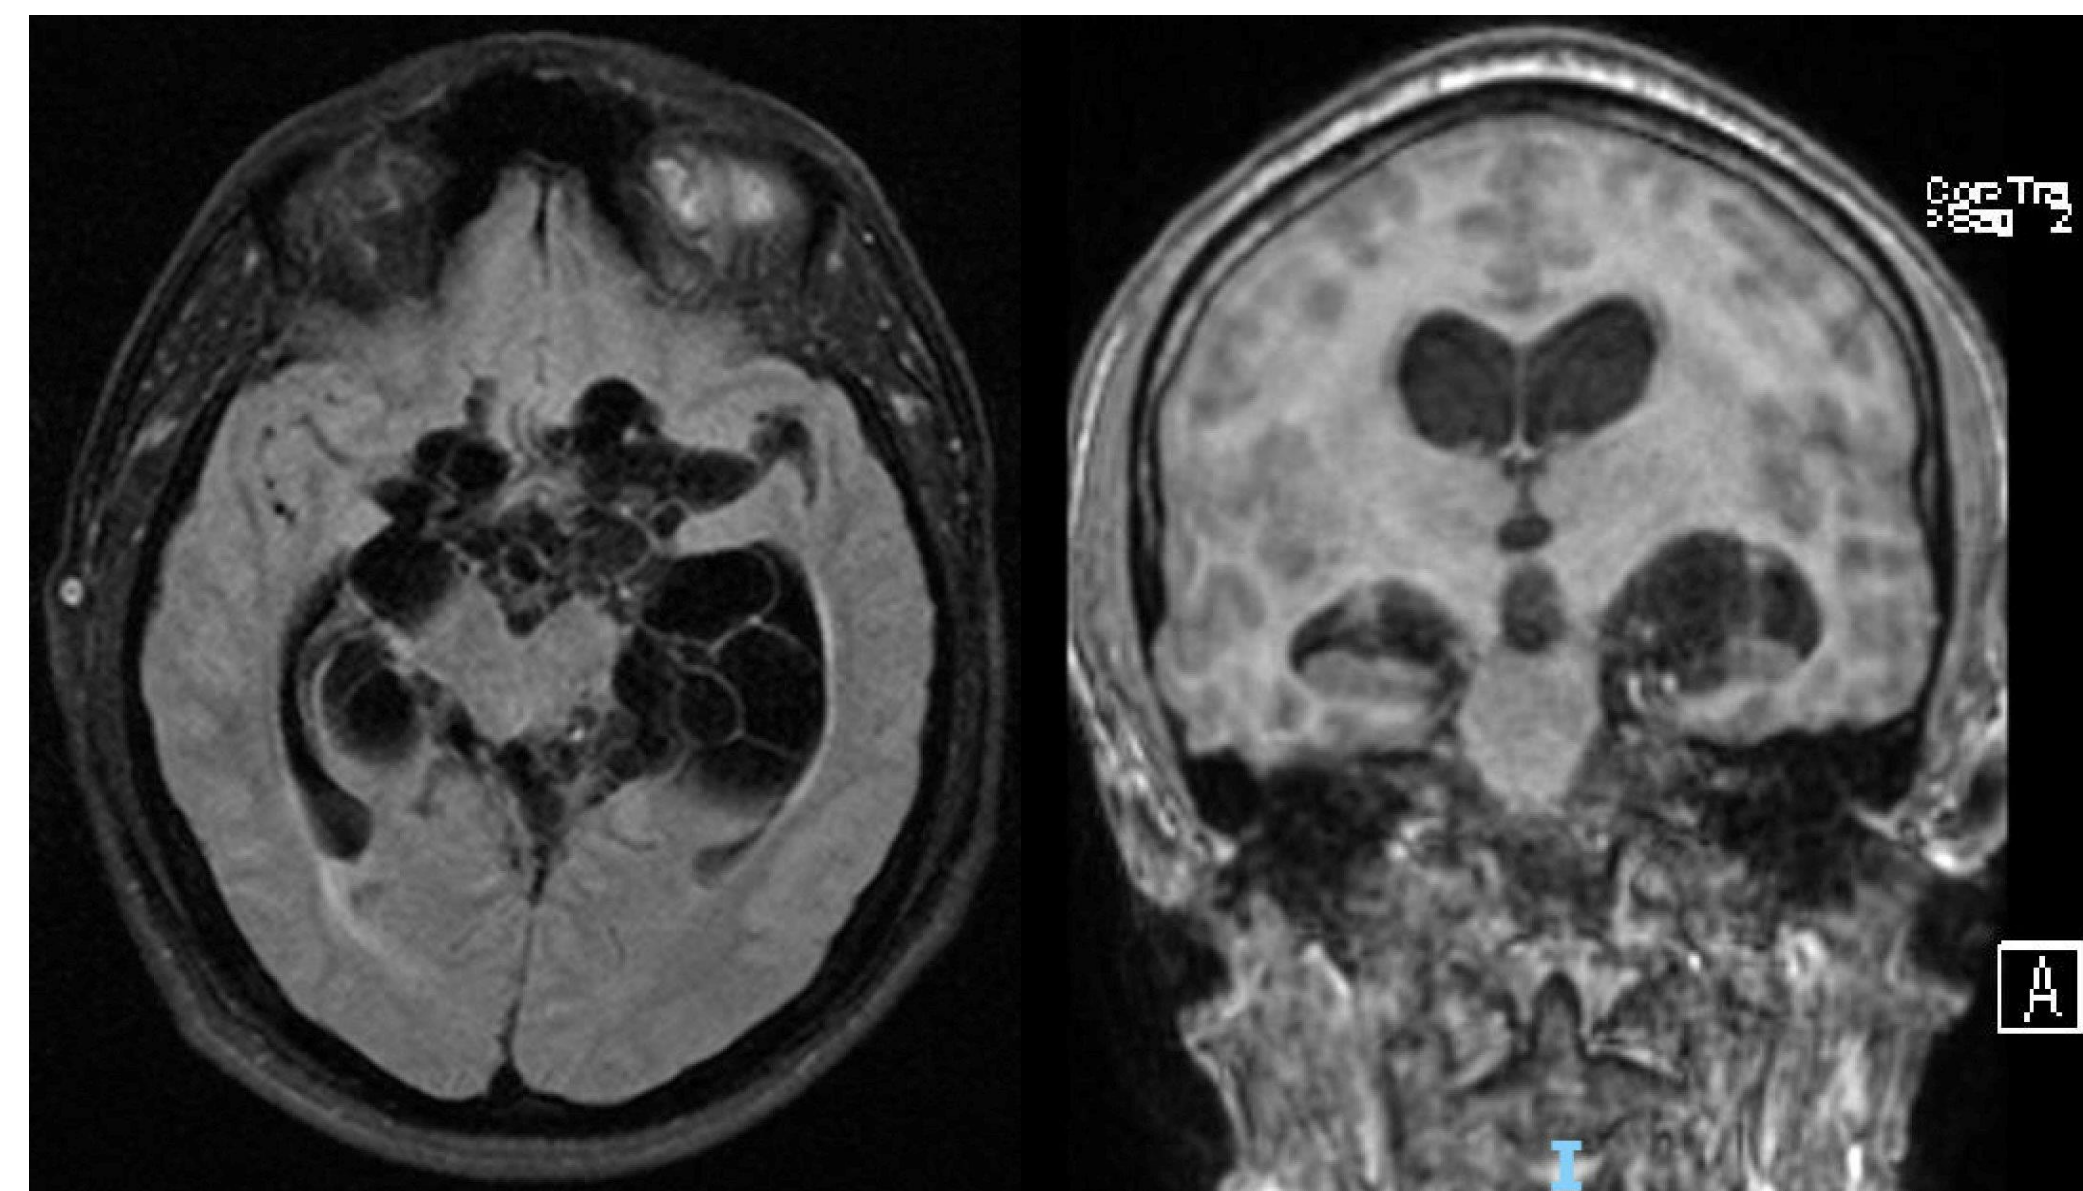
MRI T2 FLAIR imaging of the patient's head showed extra-axial loculated cysts at the level of the midbrain with associated ventriculomegaly. No conclusive lesions within the brain parenchyma were identified.
